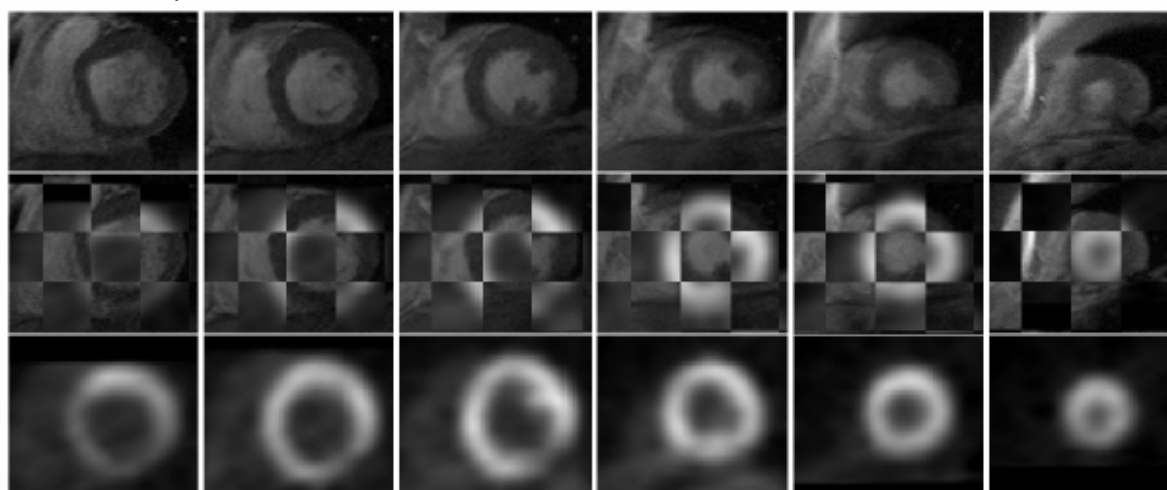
Coupes IRM-PA centrées sur la région du cœur (en haut) recalées à des images TEP-FDG (en bas) pour le cas E1 en télédiastole. La rangée du milieu est une présentation en mosaïque du recalage où l'on peut juger de la superposition des données IRM et TEP.
